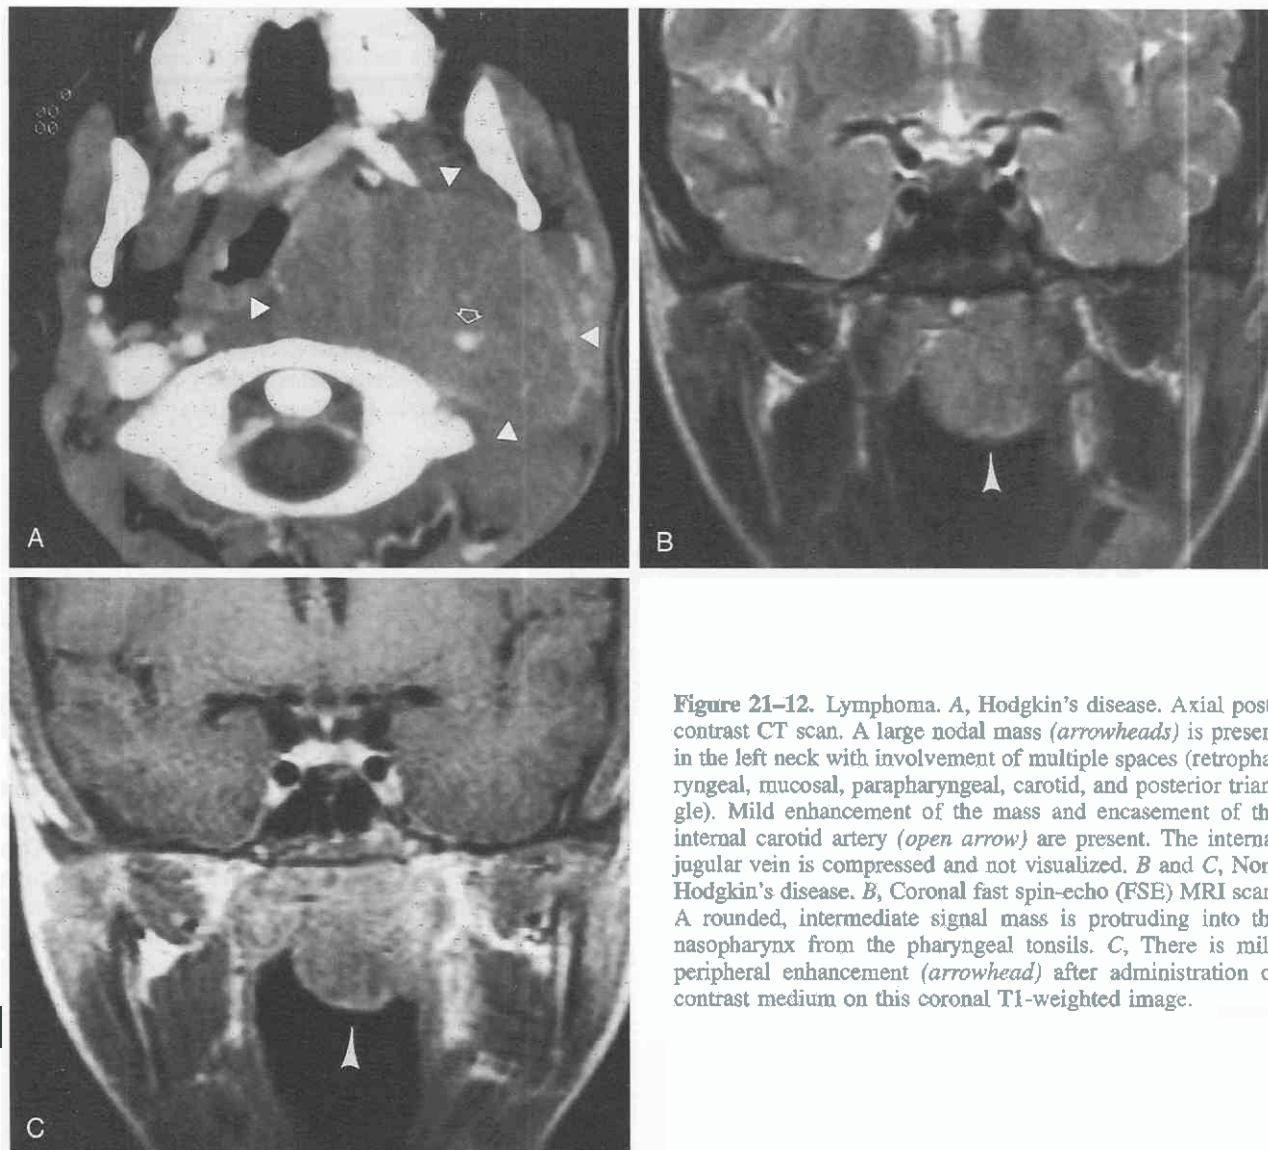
Lymphoma. *A*, Hodgkin's disease. Axial post-contrast CT scan. A large nodal mass (arrowheads) is present in the left neck with involvement of multiple spaces (retropharyngeal, mucosal, parapharyngeal, carotid, and posterior triangle). Mild enhancement of the mass and encasement of the internal carotid artery (open arrow) are present. The internal jugular vein is compressed and not visualized. *B* and *C*, Non-Hodgkin's disease. *B*, Coronal fast spin-echo (FSE) MRI scan. A rounded, intermediate signal mass is protruding into the nasopharynx from the pharyngeal tonsils. *C*, There is mild peripheral enhancement (arrowhead) after administration of contrast medium on this coronal T1-weighted image.
